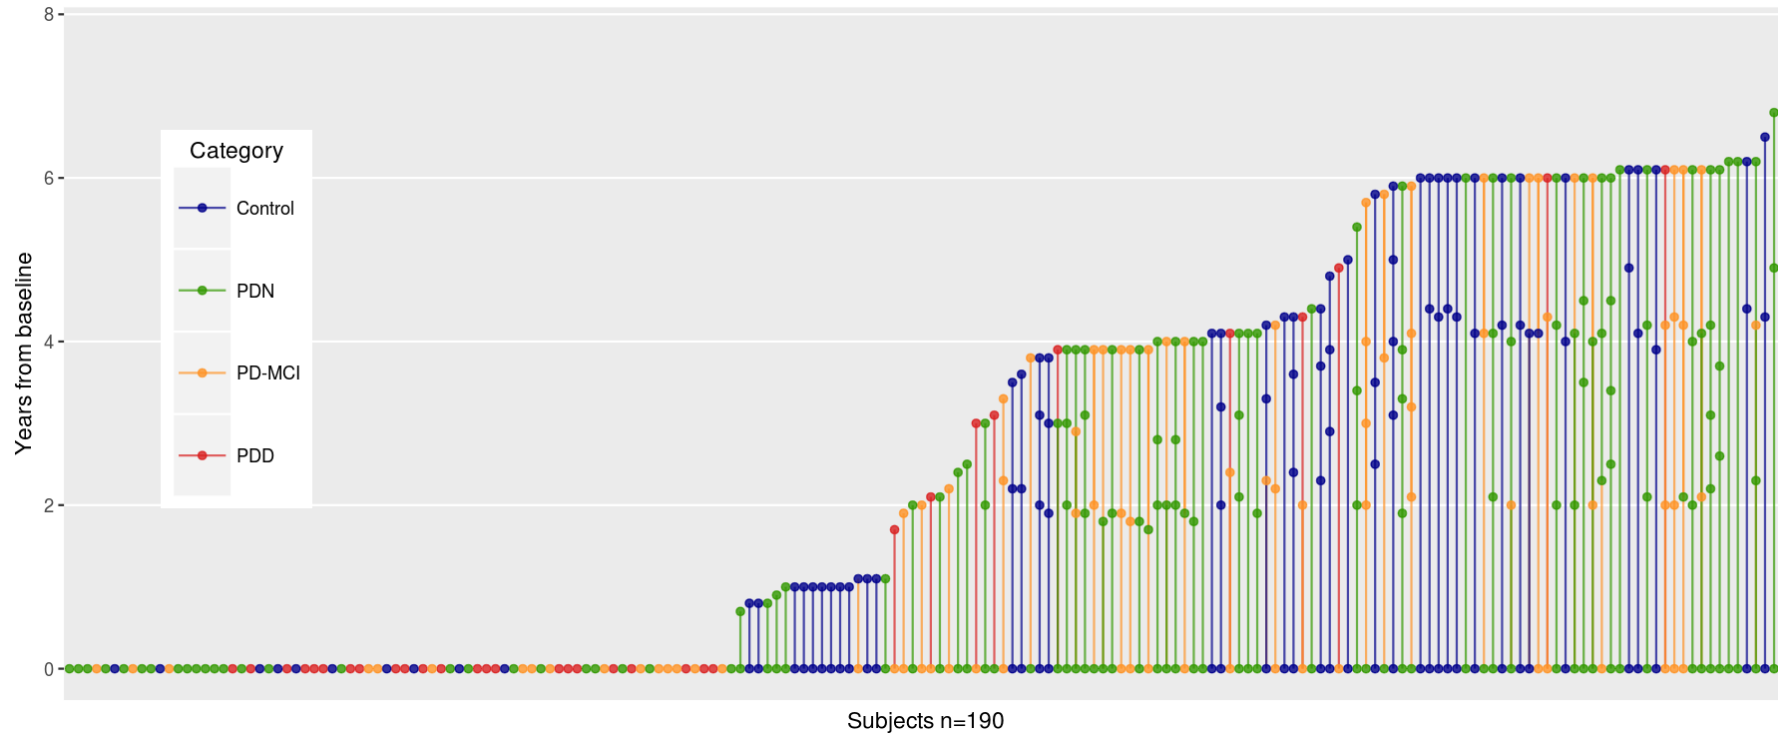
Graphical representation of the longitudinal MRI scans within this study. Each dot in this figure represents an MRI scan for an individual participant. Multiple scans within a single participant are connected with lines. Different colours have been used to indicate the individual’s cognitive status at each assessment: blue indicates Control, green indicates PDN, orange indicates PD-MCI, and red, PDD. The y axis indicates the number of years from first assessment (baseline). PDD = Parkinson’s disease with dementia, PD-MCI = Parkinson’s disease with mild cognitive impairment, PDN = Parkinson’s disease with normal cognition.
